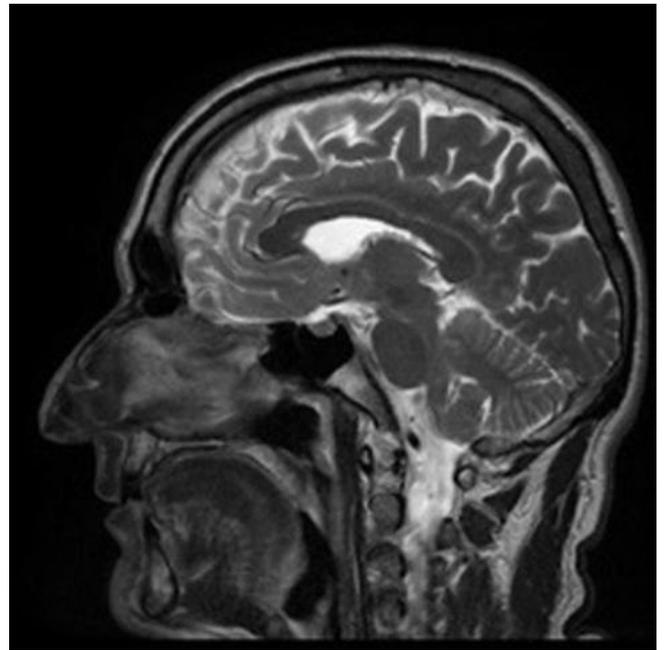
Case 2: Sagittal view of non-contrast MRI showing the nasal tip after the surgical excision of the formation.
